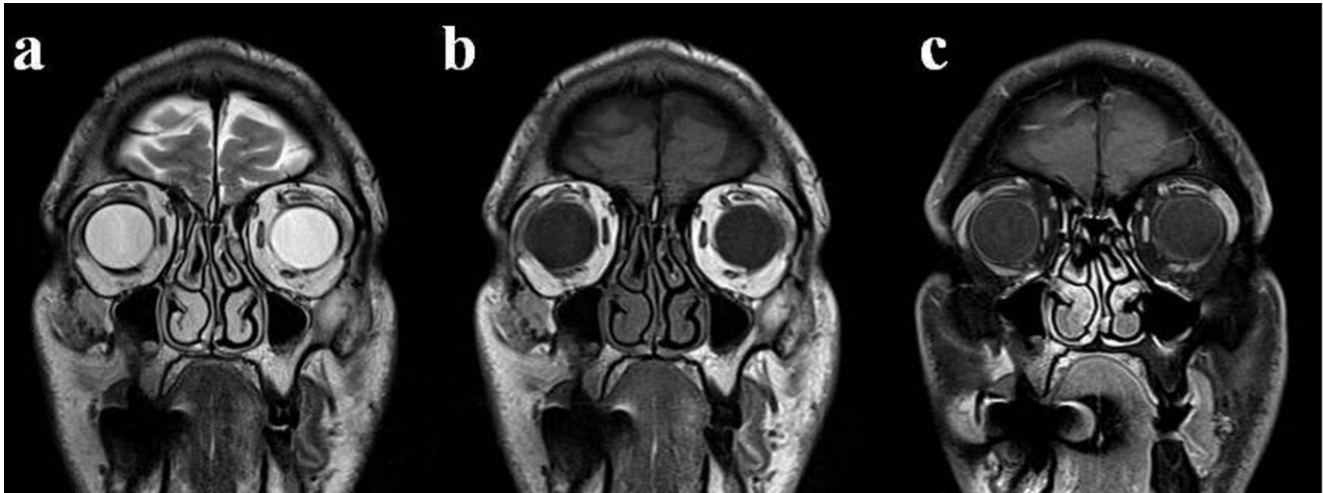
MRI orbit showing normal globe, optic nerve and extra ocular muscles.
